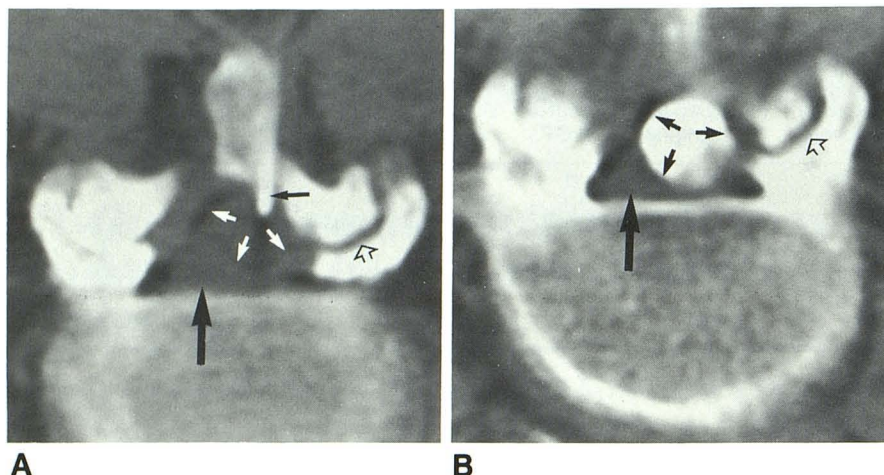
CT-guided needle aspiration biopsy and opacification of cyst with patient in prone position. A, CT confirms location of 22-gauge needle (small black arrow) within lesion (white arrows). Dural sac (large black arrow). Facet joint (open arrow). B, Opacification of cyst (small arrows) with metrizamide. Dural sac (large arrow). Facet joint (open arrow).
